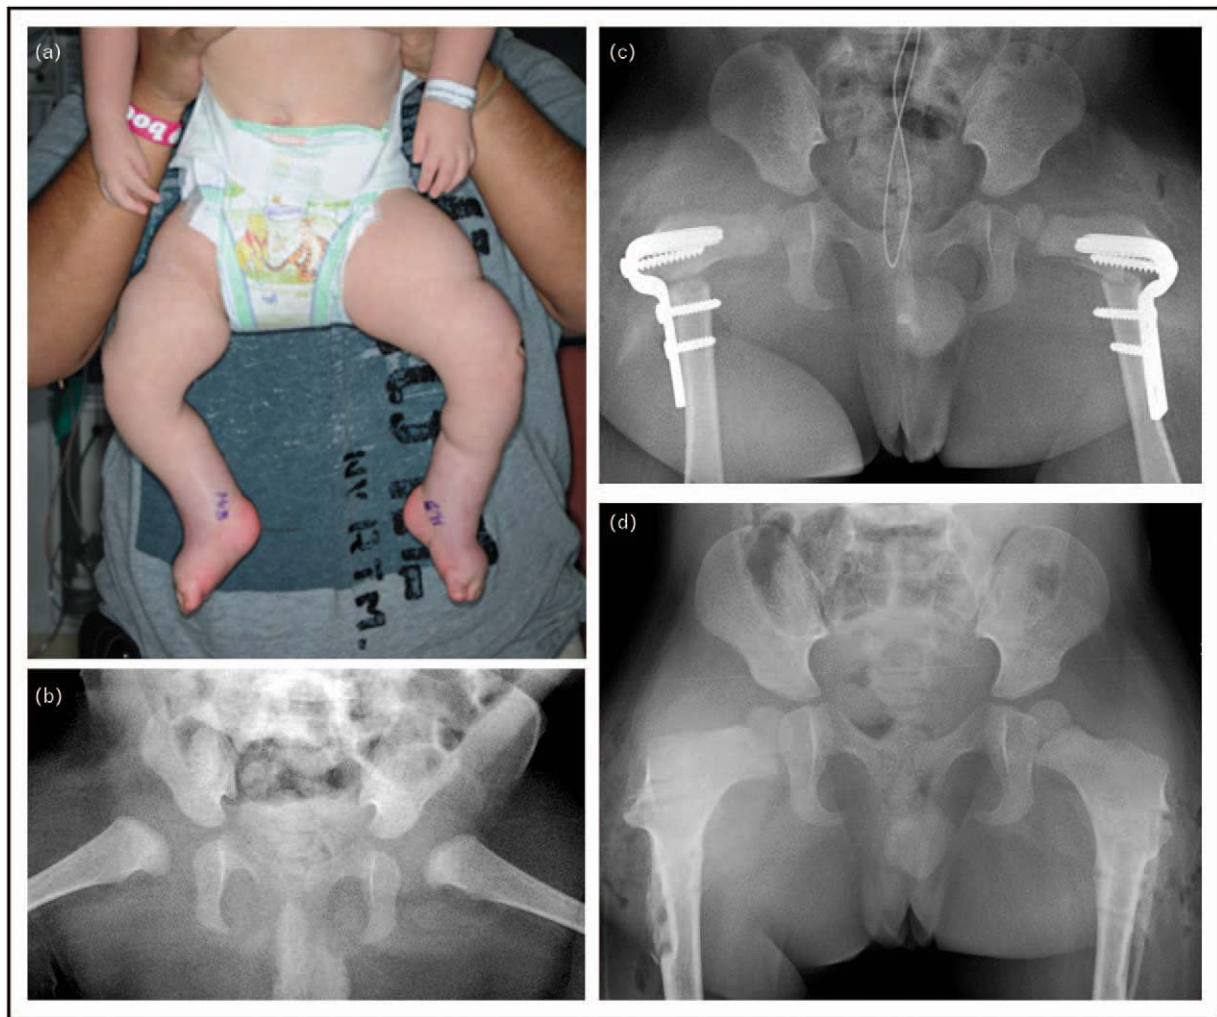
Sixteen-month-old boy with arthrogyrosis and bilateral hip contractures: (a) clinical photograph of patient's hip contractures. He had 70° hip flexion, 45° adduction, and 20° external rotation contractures. (b) Anteroposterior (AP) pelvis radiograph preoperatively, demonstrating contractures; (c) AP pelvis radiograph immediately postoperatively, following bilateral proximal femoral reorientational osteotomies. Note that the proximal femur is in essentially the same position as in the preoperative film; (d) AP pelvis radiograph after removal of hip hardware removal, 15 months postoperatively. Note the significant proximal femoral remodeling that has already occurred.
